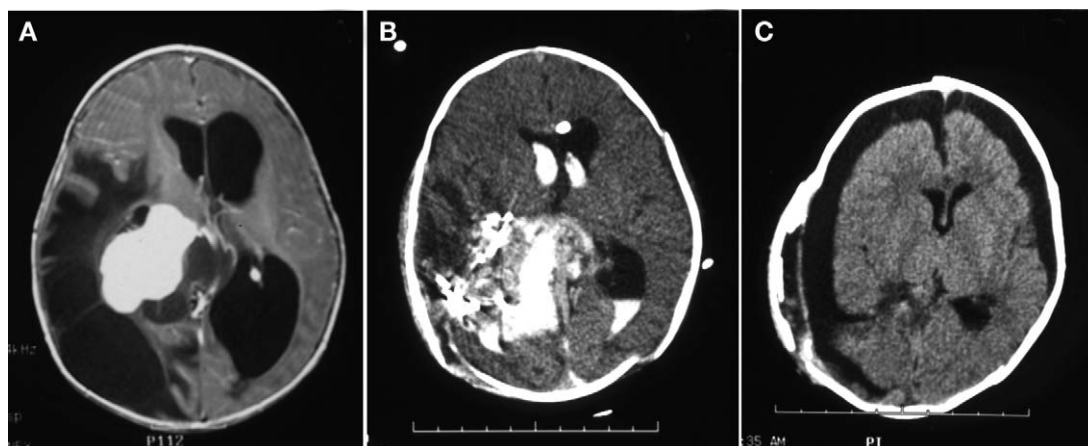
A 2-month-old child with a right atrial choroid plexus papilloma is shown. (A) The preoperative T1-weighted image demonstrates bright enhancement after injection of gadolinium. (B) During the initial attempted resection, the deeper vascular pedicle could not be secured; after two blood volumes had been lost, the procedure was stopped. The postoperative CT scan demonstrates a large intraventricular and intraparenchymal hematoma. (C) After 2 weeks, the patient was taken back to the operating room, where the residual tumor and hematoma were resected. Postoperative CT shows resolution of the hydrocephalus with large extra-axial cerebrospinal fluid collections bilaterally. The patient did not require placement of ventriculo-peritoneal (VP) shunt.
